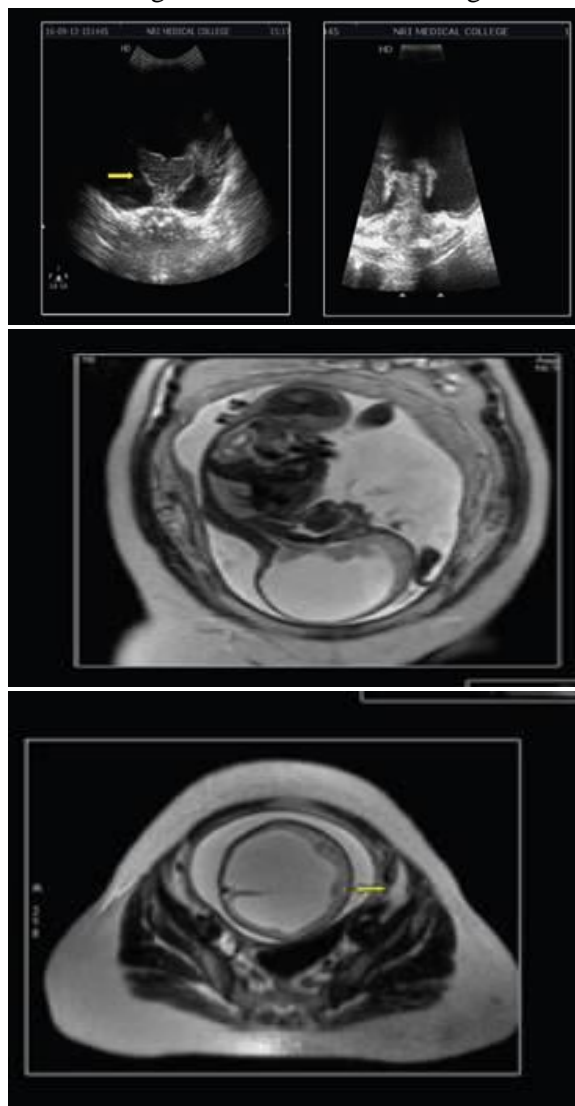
Preterm infant with maternal polyhydramnios was antenatally diagnosed with fetal hydrocephalus and further investigated with fetal MRI which revealed enlarged head gross hydrocephalus with absent inter hemispheric fissure and corpus callosum and fused thalami. Same findings were seen on neurosonogram.
